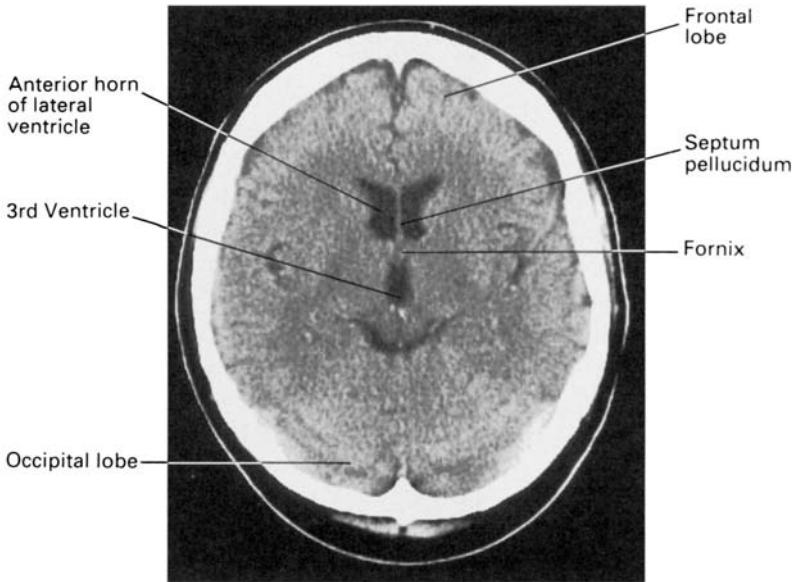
CT scan cut through the level of the third ventricle.
